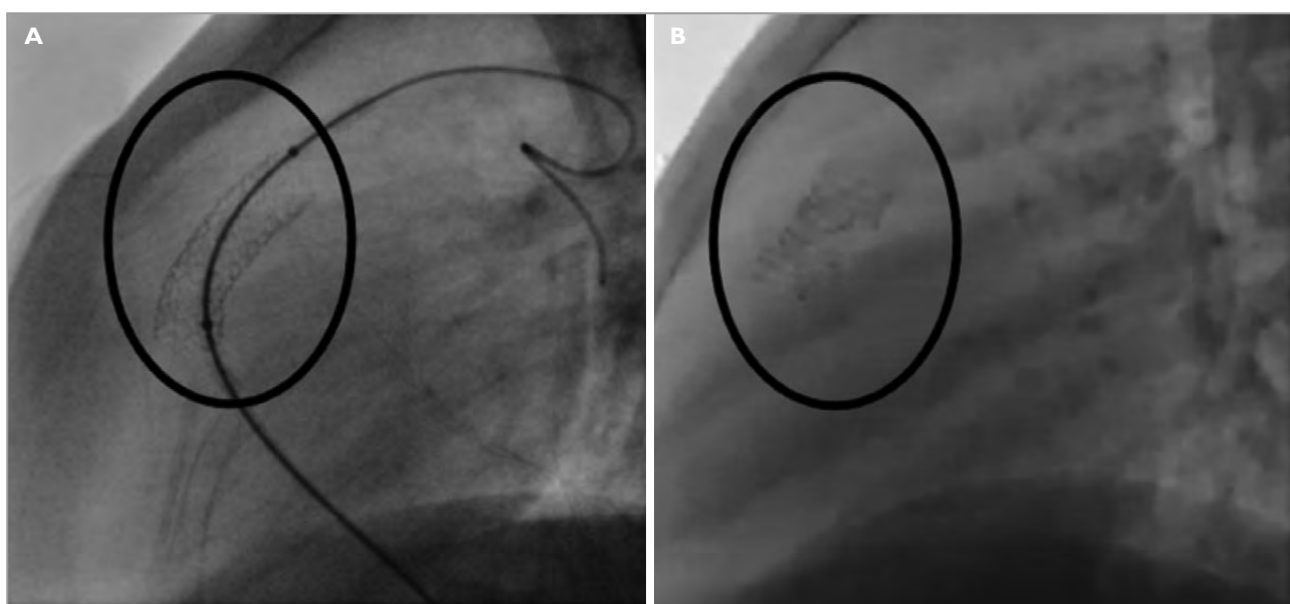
Lateral chest radiographs with right ventricular outflow tract stents in situ. A - RVOT stent intact. B - RVOT stent fracture
